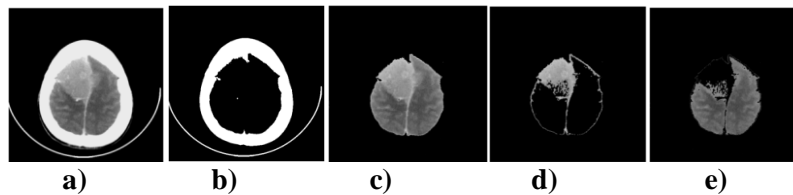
extraction of normal and abnormal tissue from CT brain images.
